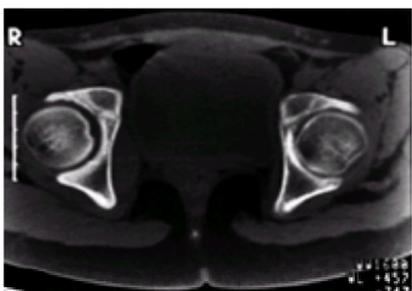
Axial computed tomographic view of the pelvis and hips in a patient with idiopathic chondrolysis demonstrates osteopenia and narrowing of the involved joint space of the affected hip.
